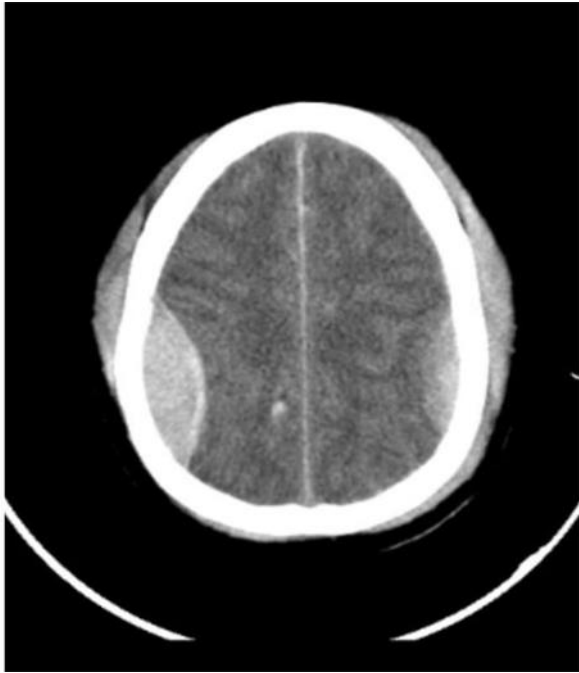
Axial CT Brain shows Parietotemporal and Parietal hematoma.
